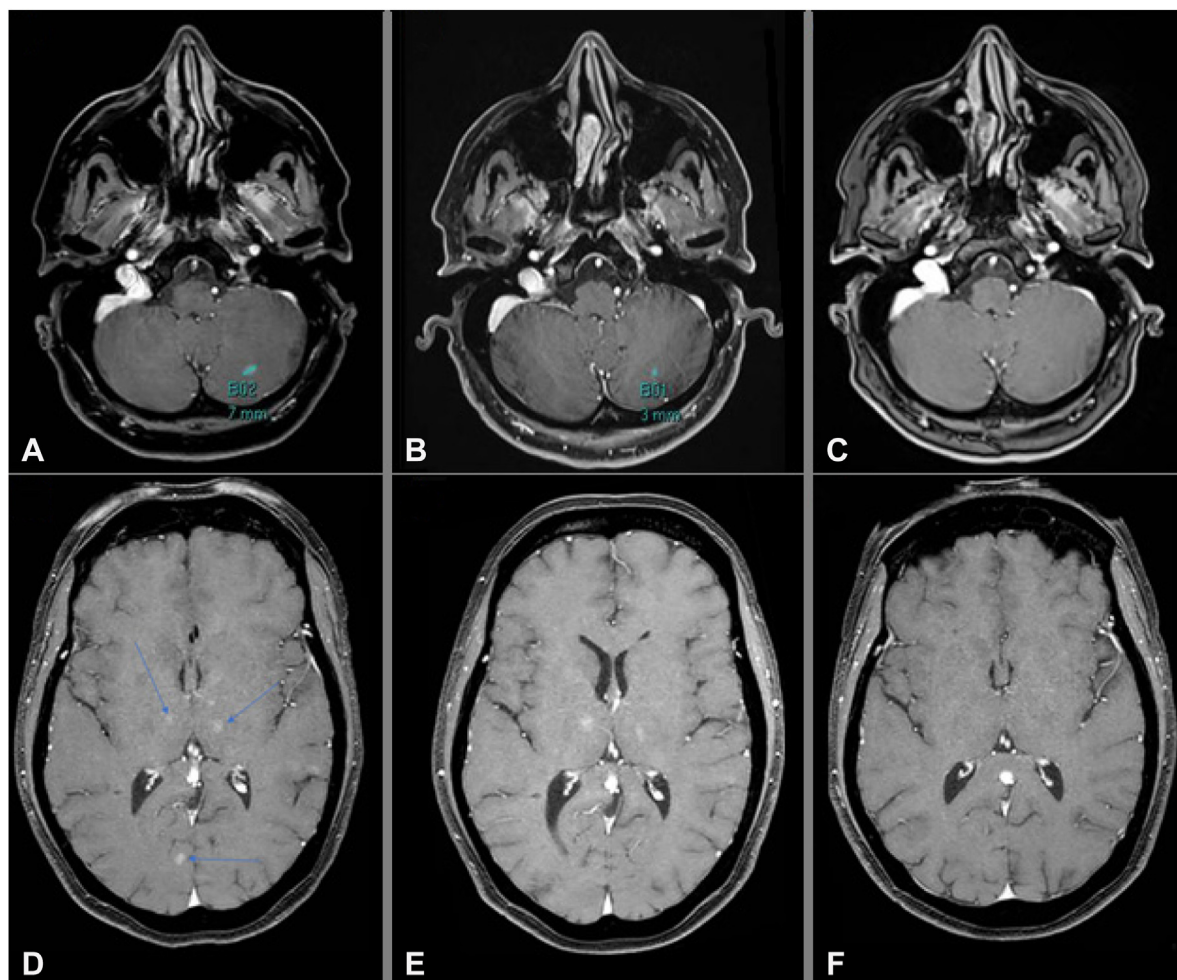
Magnetic resonance imaging of the brain. Case 1: (A) Intracranial disease progression on pralsetinib, (B) Intracranial disease response 3 weeks after selpercatinib treatment with a decrease in size of the brain metastasis from 7 mm to 3 mm, (C) Complete intracranial response 18 months after selpercatinib treatment. Case 2: (D) Intracranial disease progression on pralsetinib and 3 months after whole brain radiotherapy, (E) Intracranial disease response 6 weeks after selpercatinib treatment, (F) Intracranial disease response 5 months after selpercatinib treatment.
